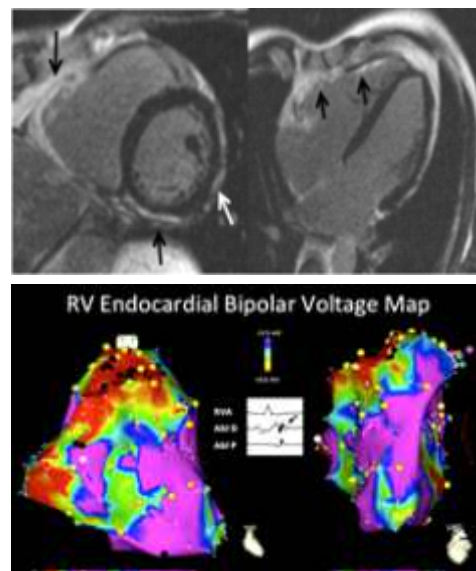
Arrhythmia substrate (myocardial scar) in ARVC (Cardiac MRI, 3D Mapping)
